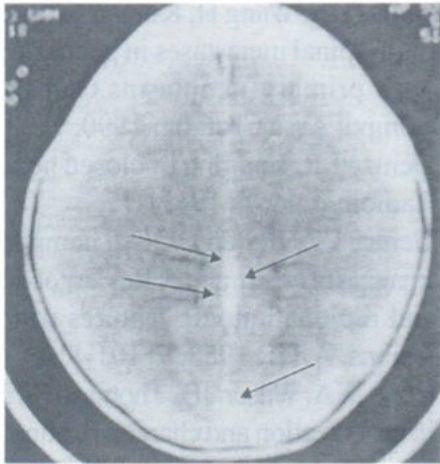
NC.CT. shows venous thrombosis as pointed by black arrows.
